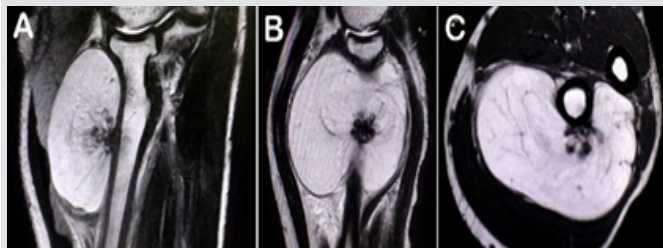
Magnetic resonance imaging images (T1 weighted) of the tumor (a) sagittal section, (b) coronal image, © axial image showing multiple hypointense bony spicules seen arising from the cortex and in continuity within the well-circumscribed mass.
